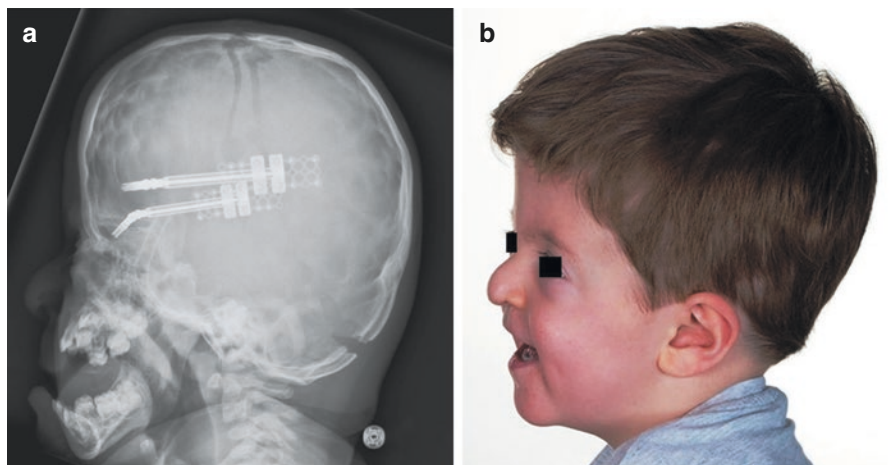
(a) Lateral skull X-ray showing bilaterally implanted distractors for dynamic cranial vault expansion. (b) Clinical outcome of the same patient at two years postoperatively
